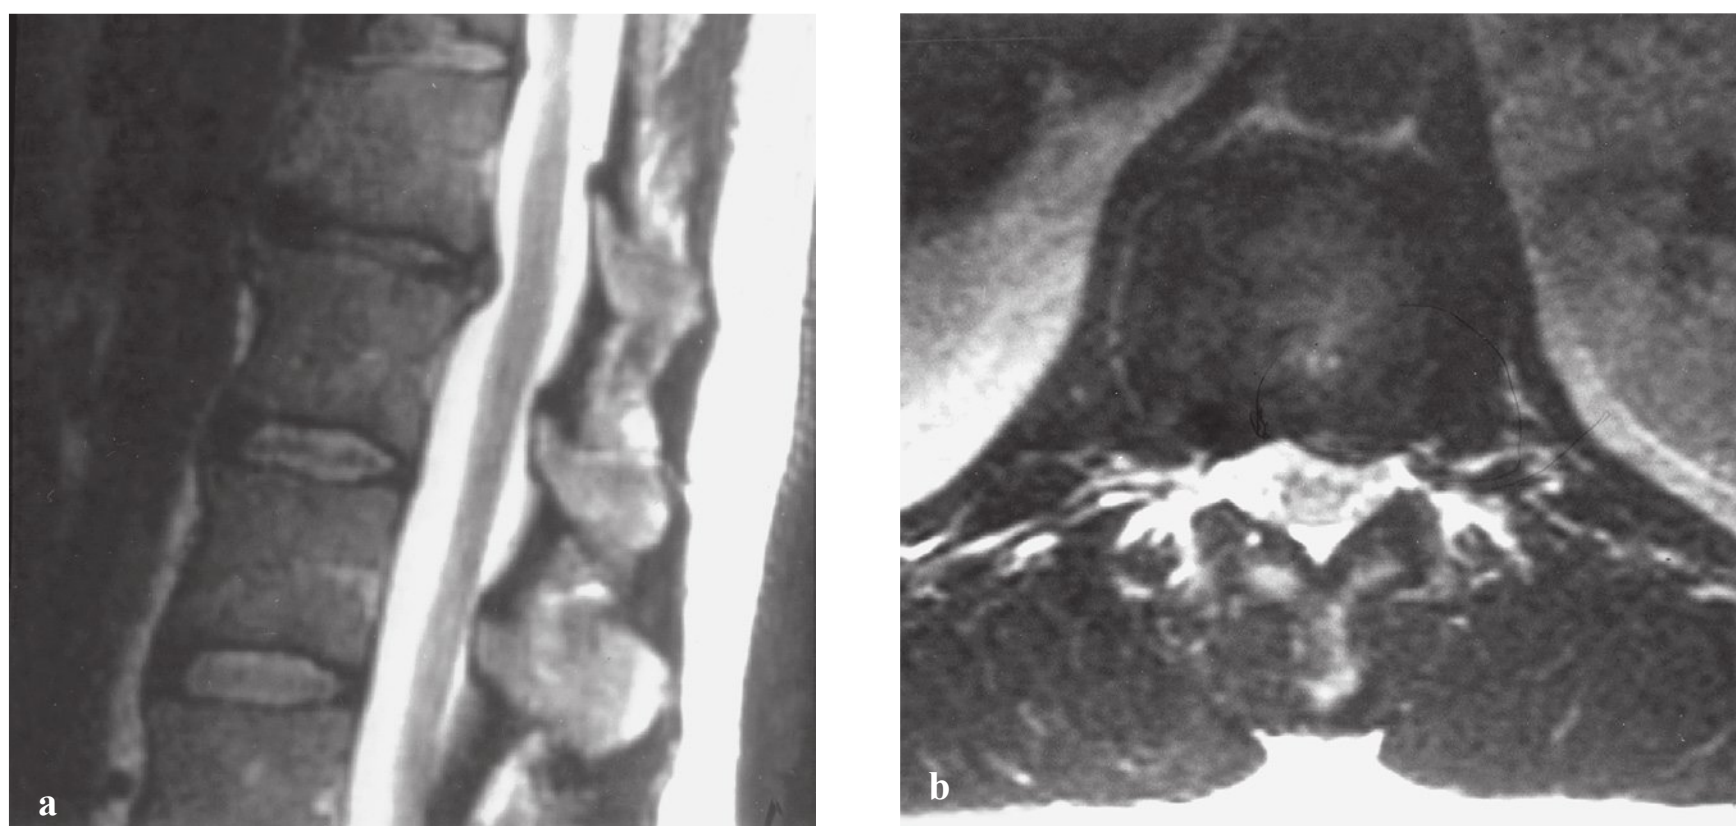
(a) T2-weighted sagittal magnetic resonance imaging (MRI) demonstrates a herniated disk at T12–L1. (b) A T2-weighted axial MRI demonstrates a left paracentral disk herniation with foraminal impingement.
